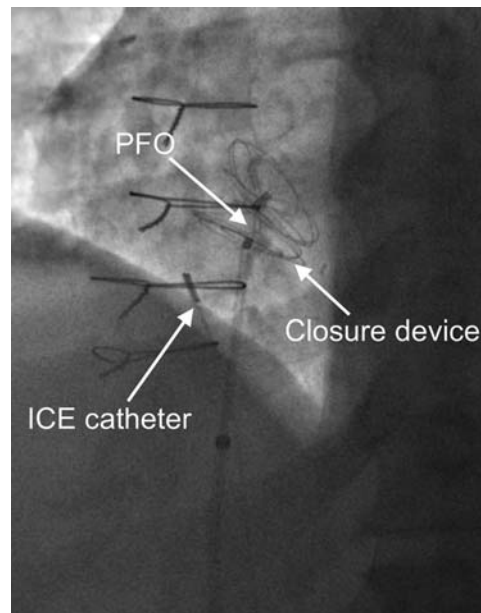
Position of the intracardiac echocardiography (ICE) catheter in relation to the interatrial septum and the closure device. Note the slight posterior tilt on the ICE catheter allowing it to visualize more of the septum. PFO, patent foramen ovale.
